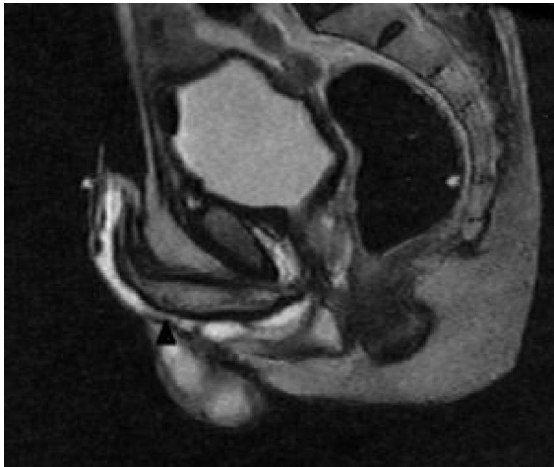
Sagittal T2-weighted MR image of the same patient demonstrates about 1.5 cm anterior urethral stricture (black arrow head).
